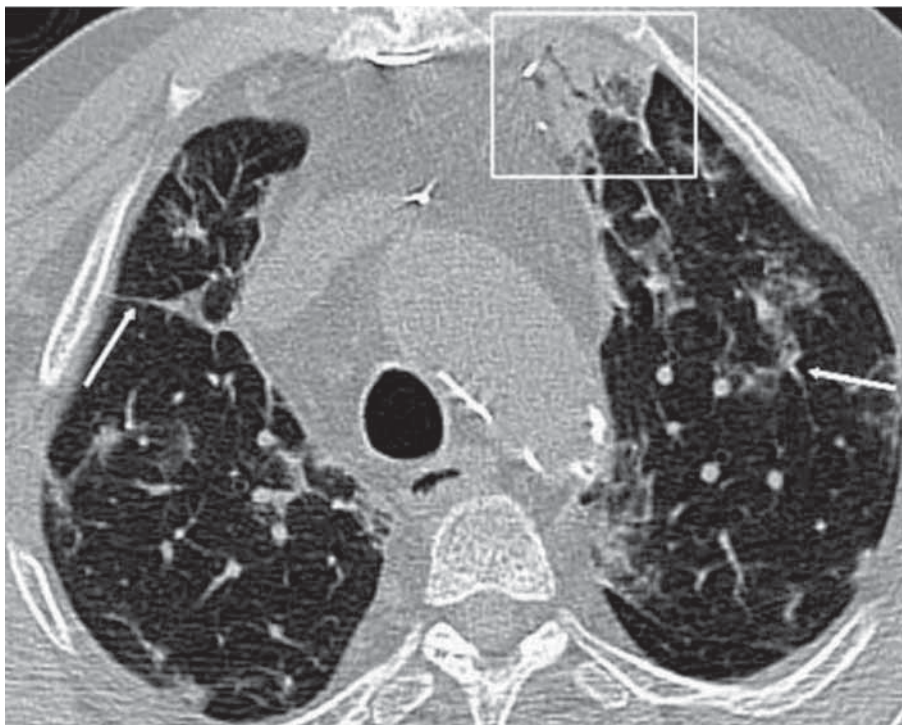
The follow-up examination performed 8 days later in the same patient described in Figure 2 showed consolidation (square), air bronchogram sign, and linear opacities. CT severity score for initial and follow-up examinations was 12 and 19, respectively.
